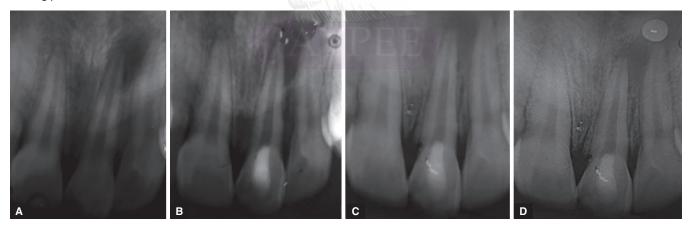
to D: Radiographs of teeth showing (A) Preoperative status; (B) Status after 3 months, (C) Status after 6 months; and (D) After 12 months of using PRF as a scaffold
